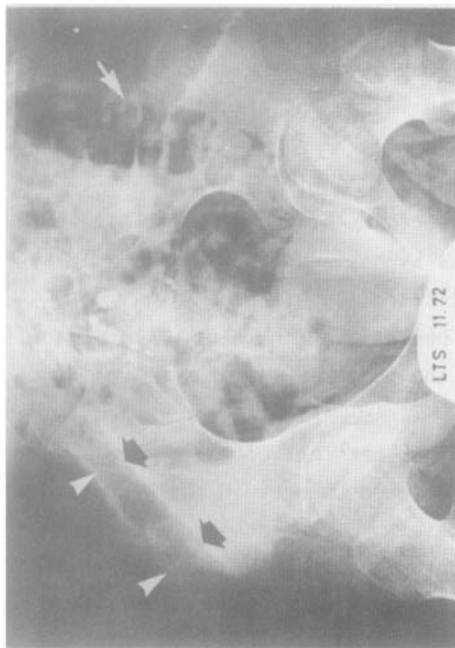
Case 98. Antero-posterior radiographs of pelvis after the patient had been in the apparatus for seven months. Note: 1) the widening of the pin tract within the iliac crest, the so-called windscreen wiper effect (arrows); 2) marked osteoporosis of the iliac crests above the pin tracts; 3) on the viewer's right side, gas in the sigmoid colon overlying the left pelvic pin tract provides a good demonstration of the relationship of the sigmoid colon to the iliac crest (arrow).
